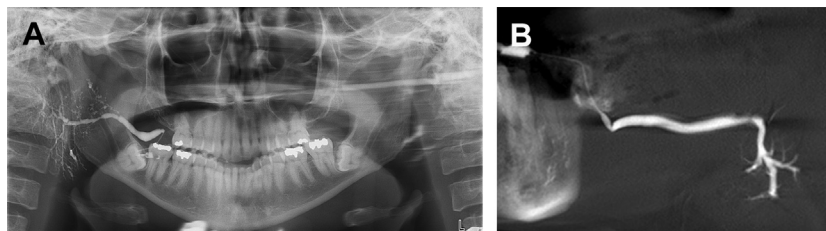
(A) Stenosis of the Wharton duct on plain film sialography. (B) Stenosis of the Wharton duct on cone-beam computed tomography sialography. (Courtesy of Oded Nahlieli, DMD, Ashkelon, Israel.)
